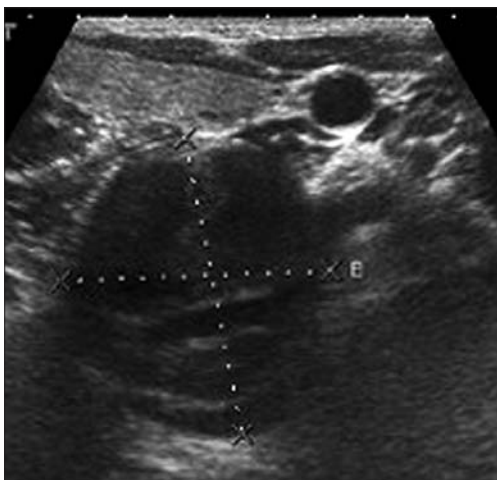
The neck ultrasound shows a lesion located posteroinferior to the left thyroid gland; the lesion has hypoechoic and hyperechoic foci and posterior acoustic enhancement.
